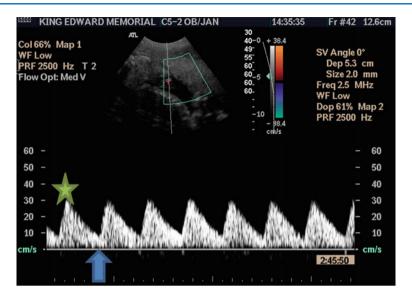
Normal: forward flow in the umbilical artery Doppler. Star—peak systolic flow, arrow —diastolic flow Published, with permission, courtesy of Dr EF Magann
